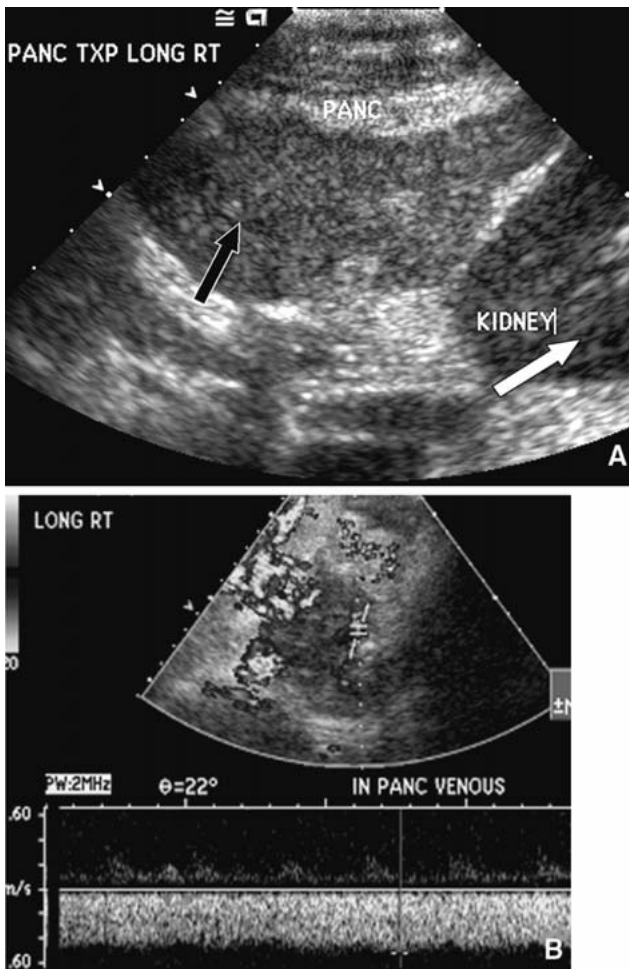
A Normal pancreatic transplant. US of a 39-year-old male 1 day after simultaneous pancreas/kidney transplant shows a normal rounded appearance of the transplanted pancreas (*black arrow*). The pancreas is slightly more echogenic than the adjacent renal transplant (*white arrow*). B Doppler US shows normal allograft vein velocity.
